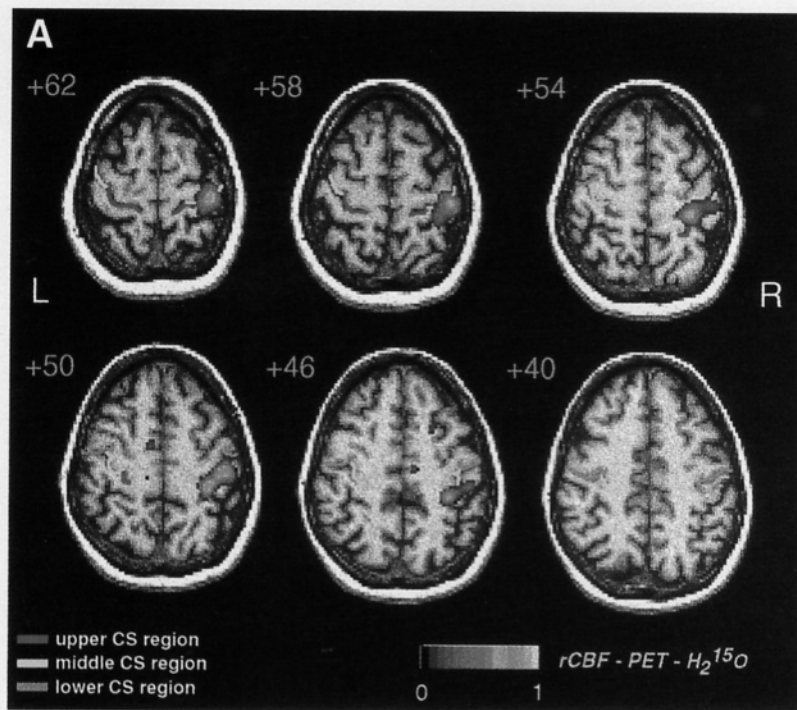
Vibration-induced PET activation of the left hand, and the right central sulcus in the same subject. Following automatic registration of PET and MR data (Mangin *et al.*, 1994), the focus of PET activation is directly superimposed on horizontal MR images (A, green-yellow spots) and on the extracted central sulcus (B, yellow circles). Note on (A) and (B) the correspondence between functionally defined hand area, and the morphologically defined middle region of the central sulcus, and their characteristic progressive shift from the lateral part of the brain at high z levels to the medial part in the depth of the sulcus at lower levels.
